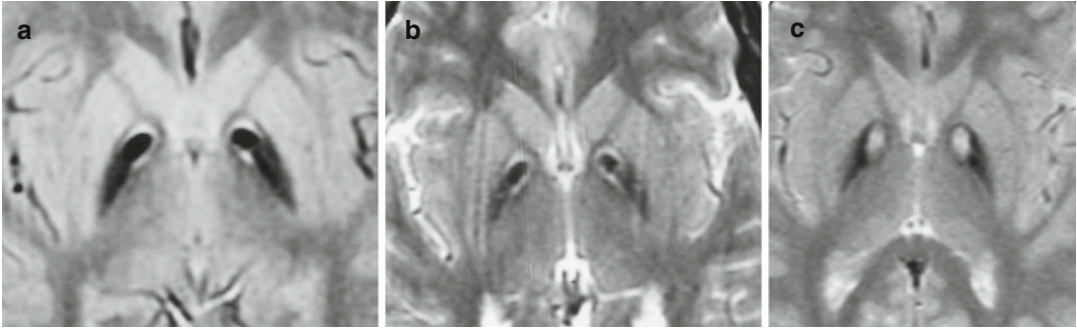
Pantothenate kinase-associated neurodegeneration (PKAN). T2-weighted images in three different cases, a-c, show the pathognomonic finding of the disease, the “eye-of-the-tiger” sign: a central hyperintense
